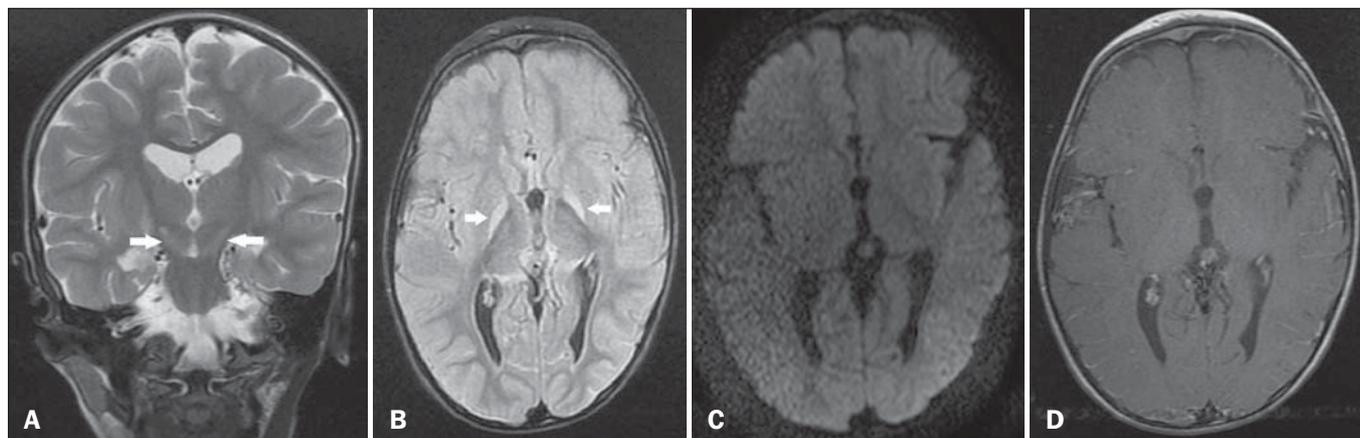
A: Coronal T2-weighted MRI sequence showing a bilateral, symmetrical hyperintense signal in the subthalamic nuclei (arrows), without a mass effect. B: Axial FLAIR MRI sequence showing a bilateral, symmetrical hyperintense signal in the globus pallidus (arrows). C: Axial diffusion-weighted MRI sequence showing no diffusion restriction. D: Axial T1-weighted MRI sequence showing no evidence of gadolinium enhancement.
